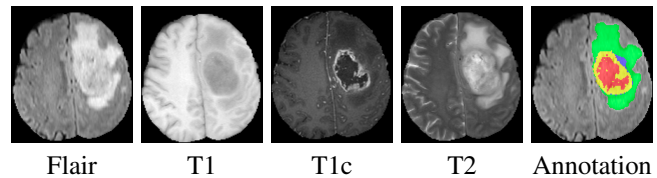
An HG brain tumor example with 4 MRI modalities (Flair, T1, T1c, T2) and experts' delineation of tumor structure: edema (green), necrosis (red), non-enhancing (blue) and enhancing tumor (yellow). Best viewed in colour.
